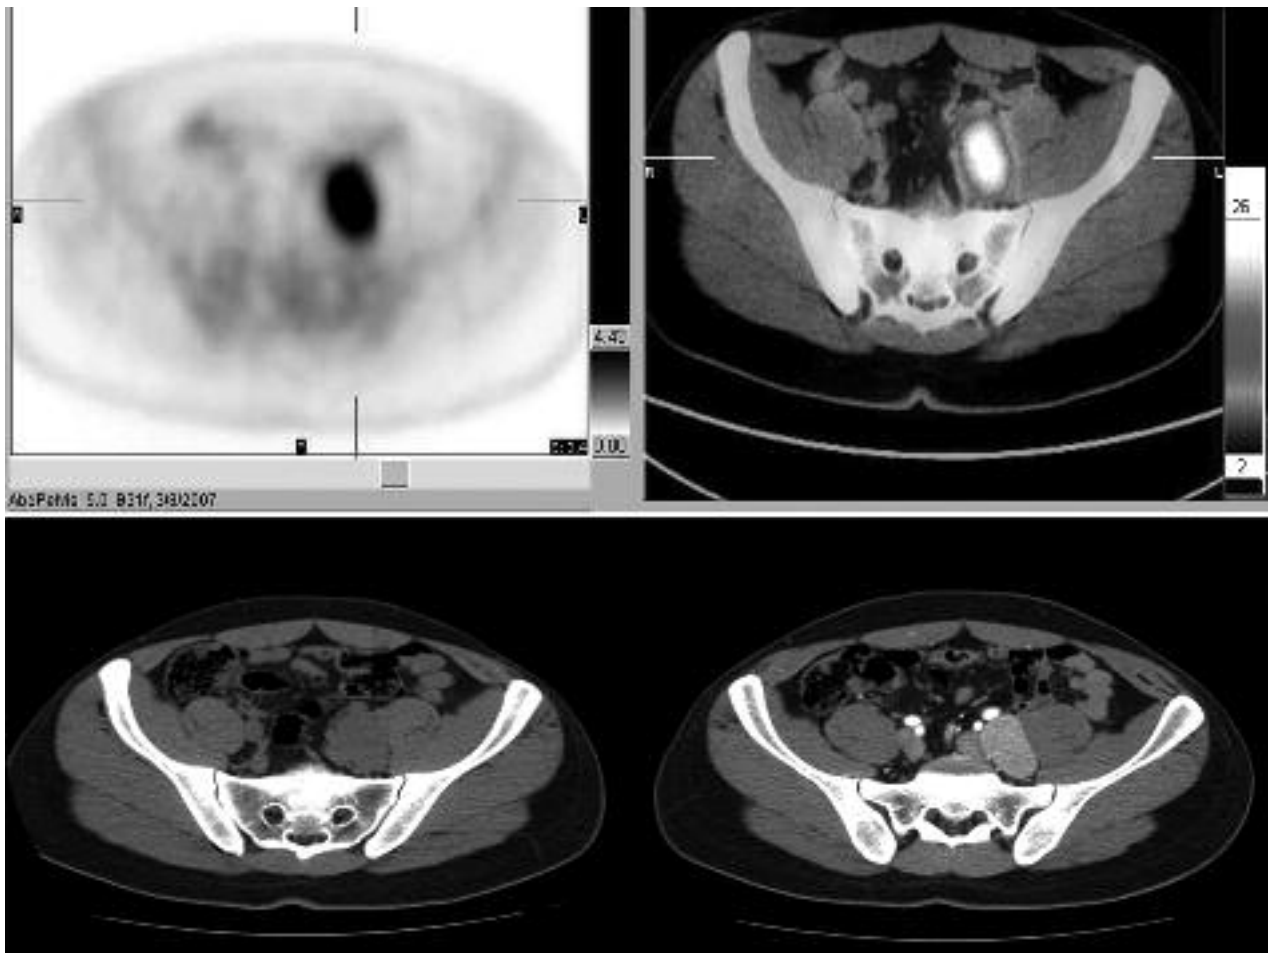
Case 1. FDG-PET demonstrated a positive area (SUV max = 6.46) in left iliac region. CT-scan confirmed an oval mass with high homogeneous enhancement after infusion of contrast
